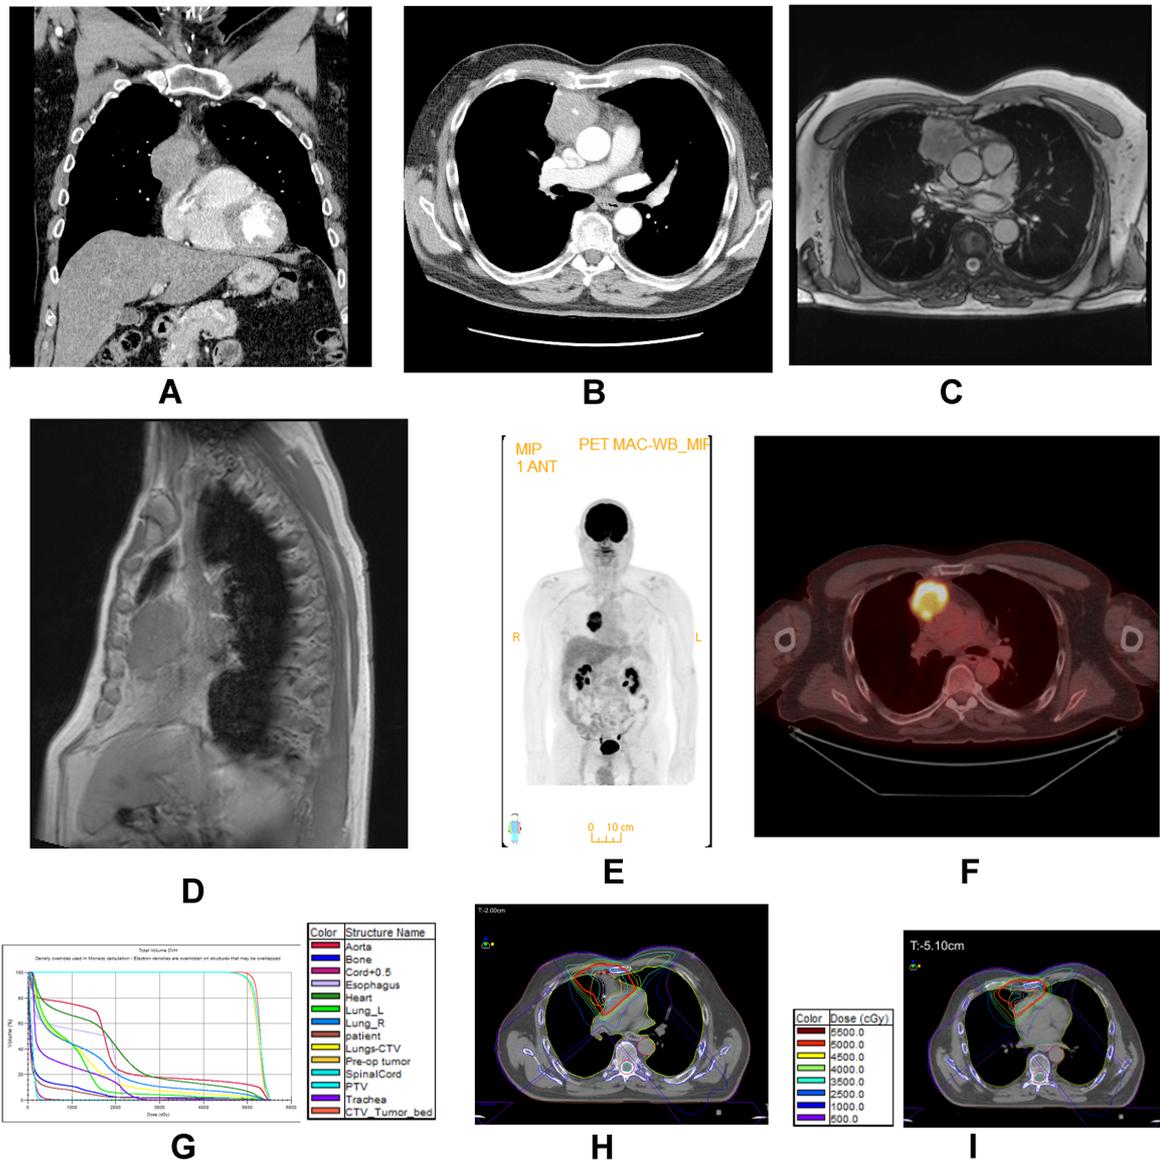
Depiction of the initial imaging: (A) Coronal CT image; (B) axial CT image; (C) axial MR image; (D) sagittal MR image; (E) PET-CT coronal image; (F) axial PET-CT image; (G) dose Volume Histogram and structure names for the 3D conformal RT plan; (H) dose distribution for the 3D plan axial image at the level of the pulmonary artery. One surgical clip is noted in this image; (I) dose distribution axial slice at the level of the atrium of the heart. (H and I) plan for a 75-year-old man with a stage III thymoma treated with PORT. He had an R0 resection (negative margins), then received 50 Gy in 25 fractions and is NED 2 years later.
